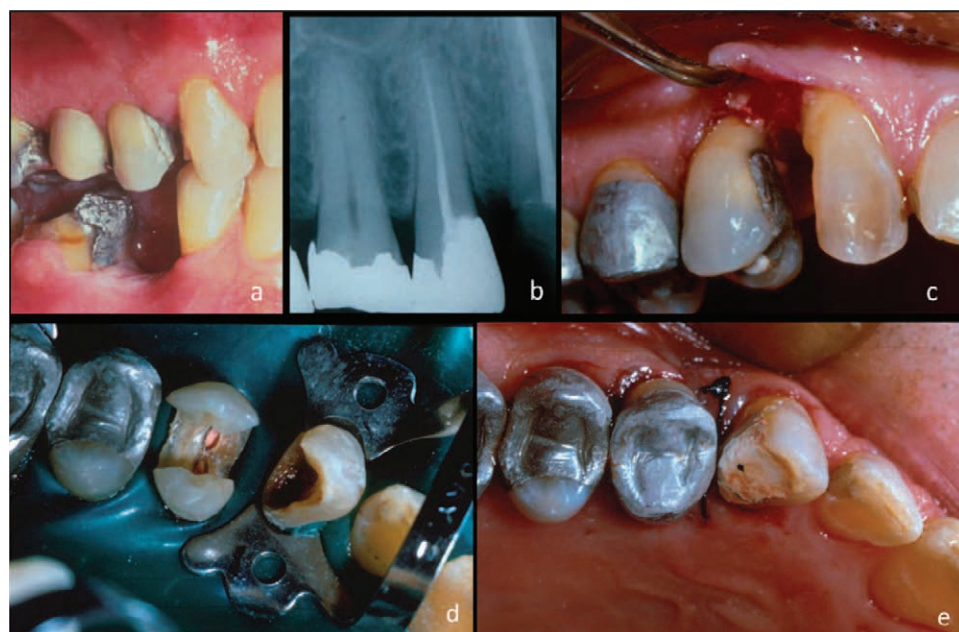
Mini-flap: (a) Preoperative photo showing tooth #5 MOD amalgam restoration with a deep mesial subgingival margin. Temporary restoration in occlusal surface is where endodontic access was prepared. (b) Radiograph of tooth #5 shows successful endodontic treatment. Mesial margin approximates osseous crest. (c) Facial-lingual mini-flap. Tissue retraction is limited to the keratinized tissue but provides excellent access to mesial restoration margin. (d) Operative field isolated with rubber dam. Note that despite location of deep mesial margin and execution of mini-flap the rubber dam provides complete isolation and accessibility of what once was the deep subgingival margin. (e) Amalgam build-up completed; single suture placed in interdental papilla.
